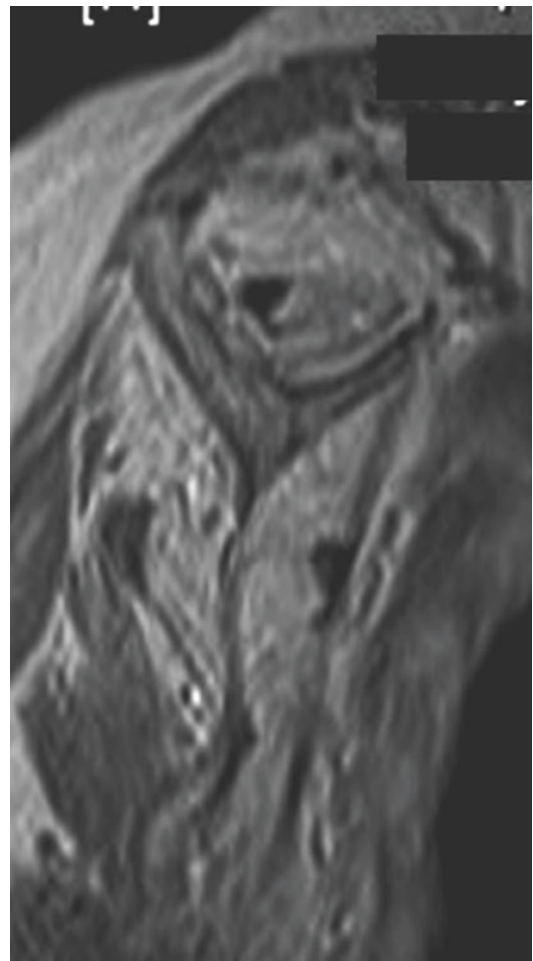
Fatty muscle index involving the three main muscles of the rotator cuff—Grade 4 as seen on parasagittal T1 MR image
